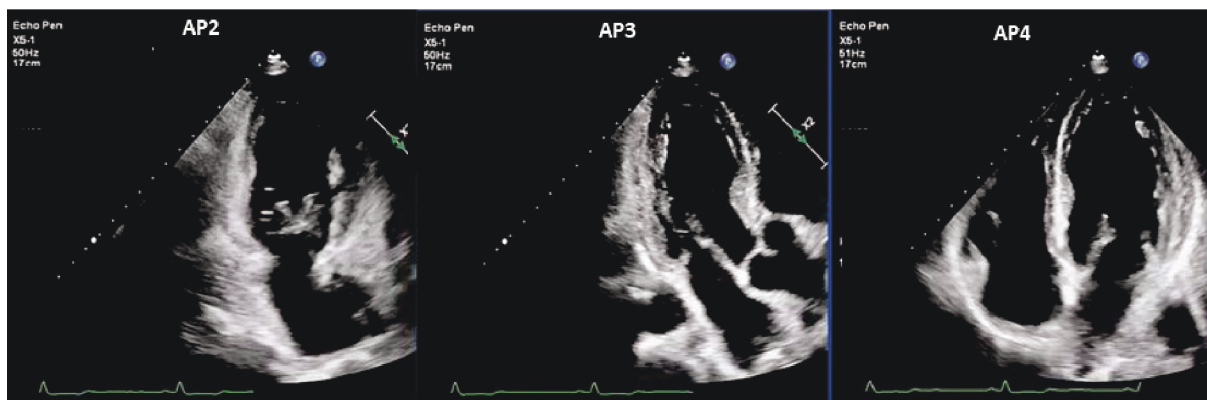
Example of optimal apical 2,3, and 4 chamber images for GLS analysis. Endocardial borders are visualized over the cardiac cycle, apex not foreshortened, frame rate is 50 fps, and depth and sector width the same in all three.
